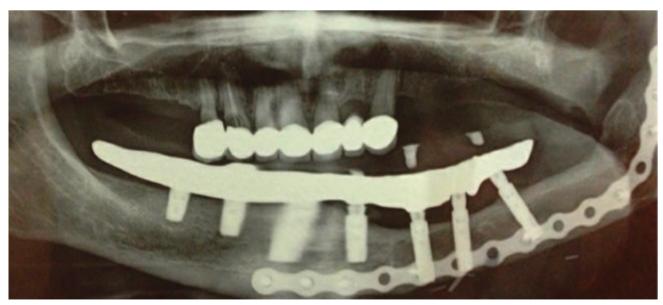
Orthopantomography in which it shows the correct adaptation of the hybrid prosthesis placed on the implants.
